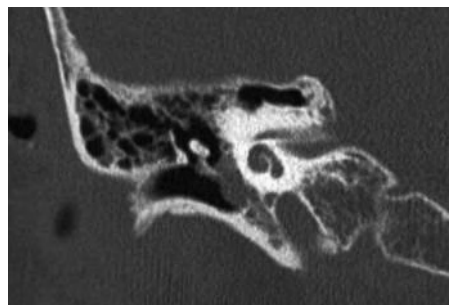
CT finding. The soft tissue density area extending from right middle tympanum to the eustachian tube without any destruction of ossicles was revealed.
